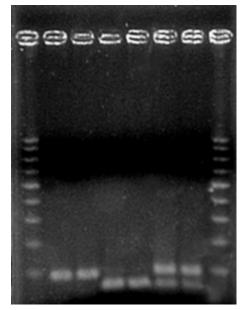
PCR-RFLP analysis for CD14/-260 genotypes. Extracted genomic DNAs were subjected to PCR amplification specific for a CD14 region followed by a Hae III digestion and then electrophoresis on an agarose gel. The presence of a band (318 bps), 3 bands (318, 172, and 146 bps), and 2 bands (172 and 146 bps) indicated homozygous TT, heterozygous CT and homozygous CC, respectively.
